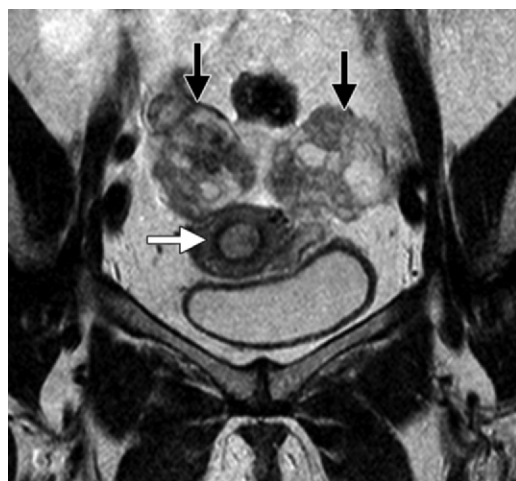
Stage IIIA endometrial carcinoma (mixed high-grade serous papillary and grade 3 endometrioid adenocarcinoma) in a 71-year-old woman. Coronal T2-weighted MR image shows an endometrial tumor with intermediate signal intensity within the endometrial cavity (white arrow) and enlarged ovaries (black arrows), which demonstrate abnormal heterogeneous signal intensity, a finding consistent with ovarian metastases.
